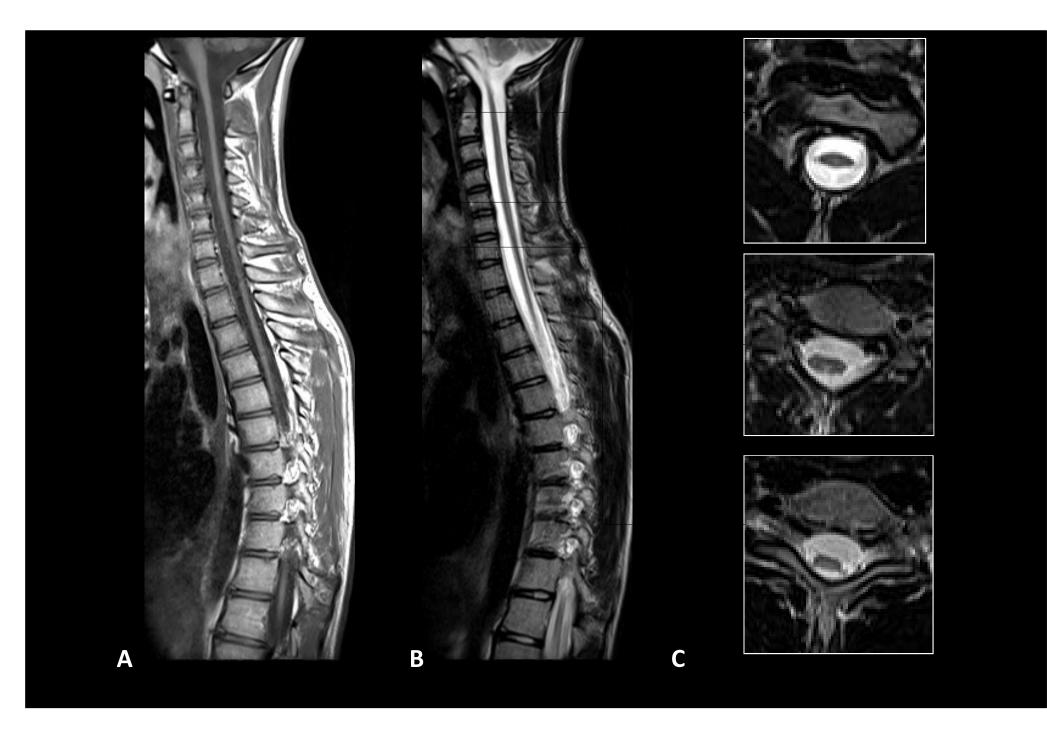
Spine MRI, sagittal T2WI (A) and T1WI (B), axial T2WI (C) (there are some movement artifacts). The atrophy of the medulla oblongata extends downward to the entire cervicodorsal spinal cord (A, B), that appear "flattened" in the axial images (C). There are no clearcut signal abnormalities in the atrophic spinal cord (the subtle hyperintensity in the central cord, better visible at C5 level, is probably related to the normal gray matter signal).
